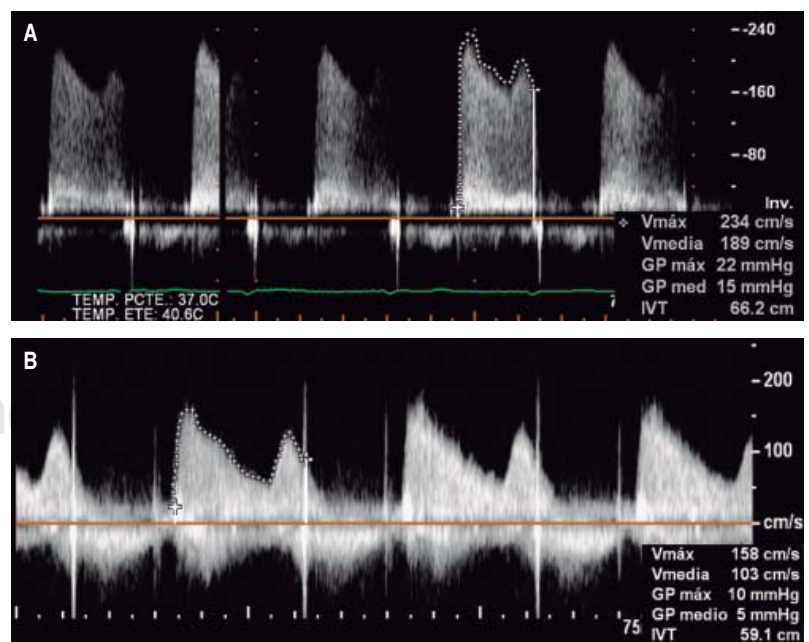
Transesophageal echocardiogram showing decrease of the maximum and mean gradient of the mitral valve, before the procedure (A) and after it (B).
